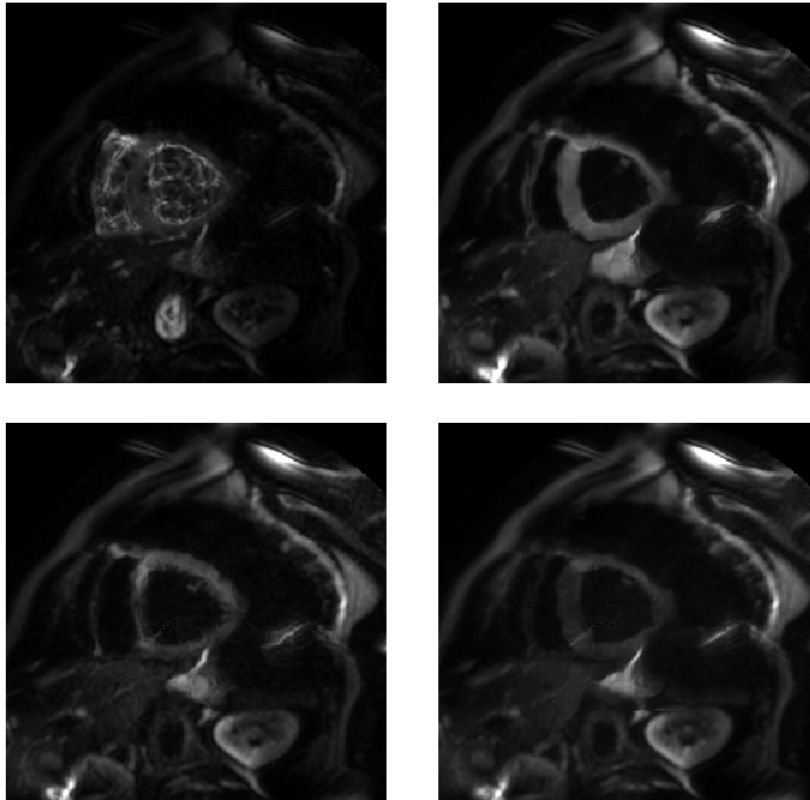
Axial slices of registered DWI sequence for b -values of 0, 50, 150 and 300 s/mm^2 (from upper left to bottom right).
